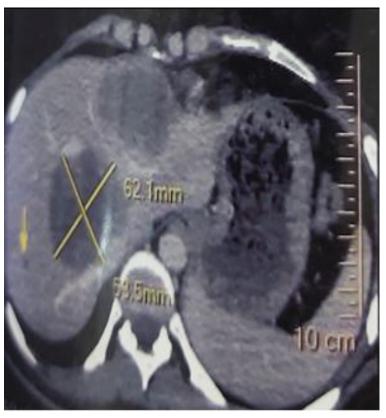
Axial contrast CT scan of abdomen showing hypodense necrotic nodular enhancing lesions within both lobes of liver, largest one at right lobe
